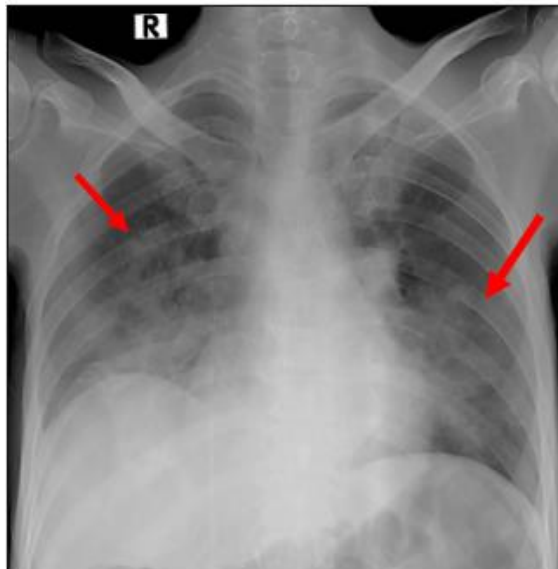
A pre-treatment chest X-ray revealed bilateral infiltrates near the paracardial border in both lung fields (red arrow). Cavitory lesions appeared in the right side hemithorax.
